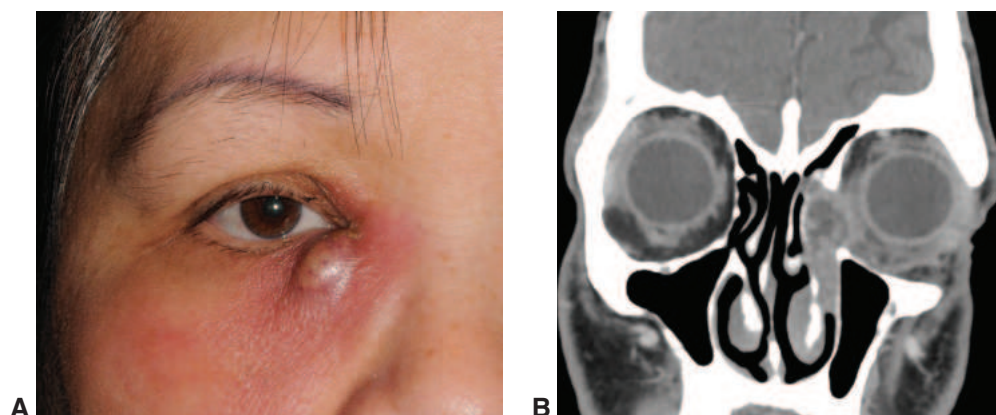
Acute dacryocystitis. A, Acute dacryocystitis of the right side associated with NLDO. B, Coronal CT scan showing acute dacryocystitis of the left side. (Part A courtesy of Bobby S. Korn, MD, PhD; part B courtesy of Steven M. Couch, MD.)
